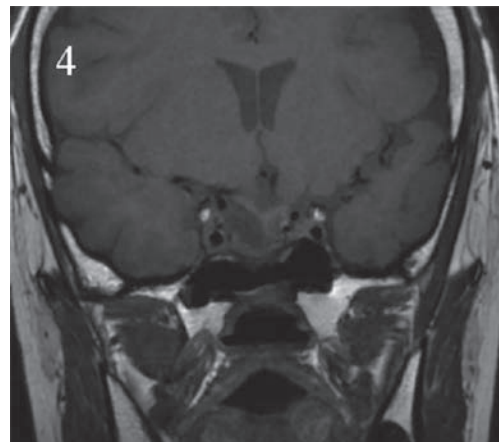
Postoperative MRI demonstrated optic nerve decompression with the removal of the lesion
